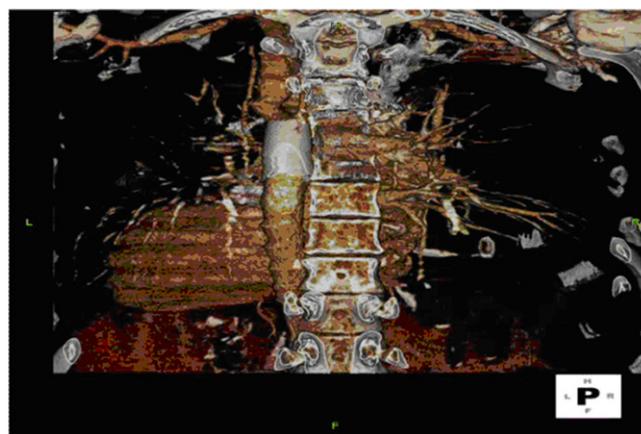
Post-operative CT angiogram at 6-month post-intervention displaying a significant improvement in aortic calibre to 16 mm.
